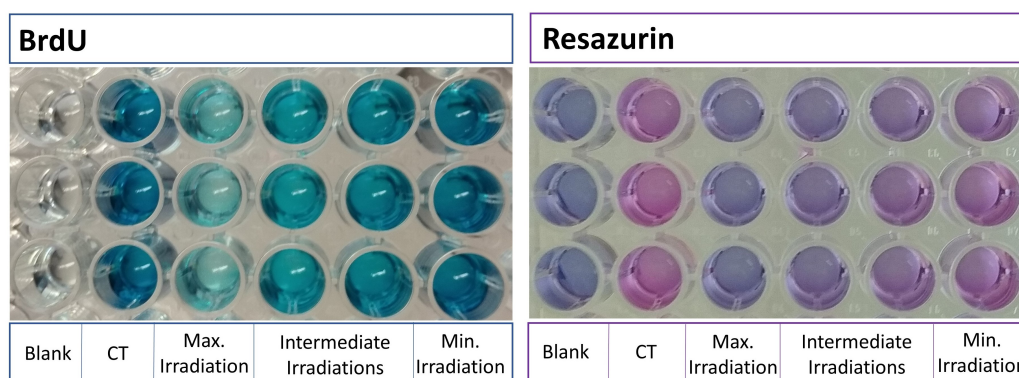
Plates with irradiated cells after two different colorimetric assays. The same number of cells were seeded in each well. The BioRad iMark™ microplate absorbance reader will read the wavelength corresponding to each color emission. In BrdU, the blank sample (only culture medium) is mostly transparent, while the control sample (CT), where most of the cells seeded have grown, is dark blue. Hence, in BrdU, the lower the number of cells in the well, the lighter the blue color of the sample. In Resazurin assay, the blank sample is dark purple while the control one is pink. Hence in Resazurin assay, the fewer the number of cells in the well, the darker the color observed.
